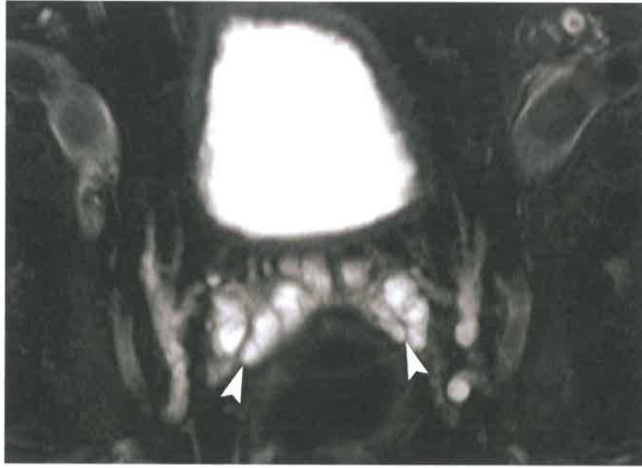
Normal Seminal Vesicles. T2-weighted axial plane MR with fat saturation shows the normal high signal intensity of the fluid-filled seminal vesicles (arrowheads).
